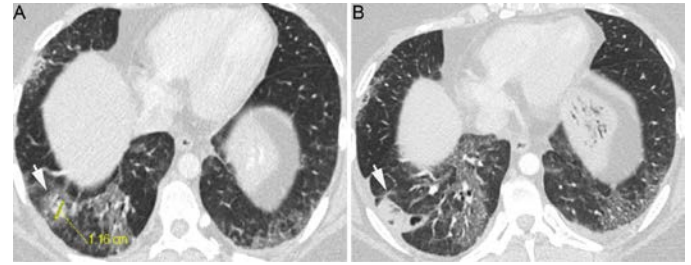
Axial CT images of the right lower lobe lung nodule. IA. Pre ablation image. B. Post ablation image. Interstitial lung changes remain constant.
